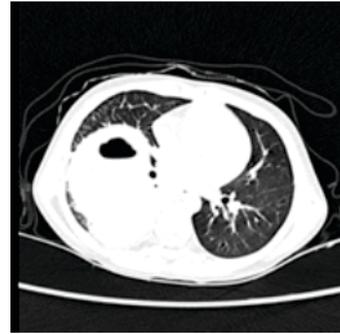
CT scan of patient on admission
